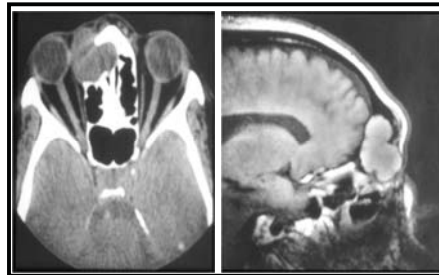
Nasal fossa and paranasal sinuses CT scan in axial and coronal sections evidencing image of left frontoethmoidal region with displacement of ocular globe on the left (proptosis).
